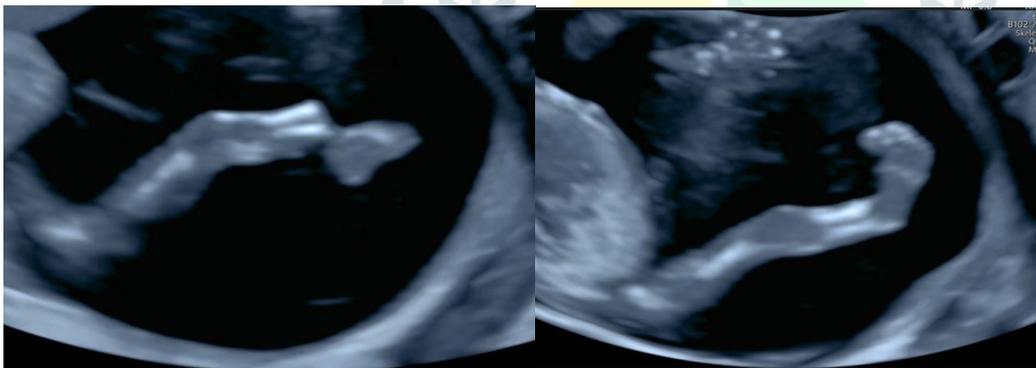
a 4D VCI skeletal mode ultrasound showing the fractured appearance of right leg with short tibia -fibula and hanging foot .Figure 2b showing the normal left leg in comparison.
